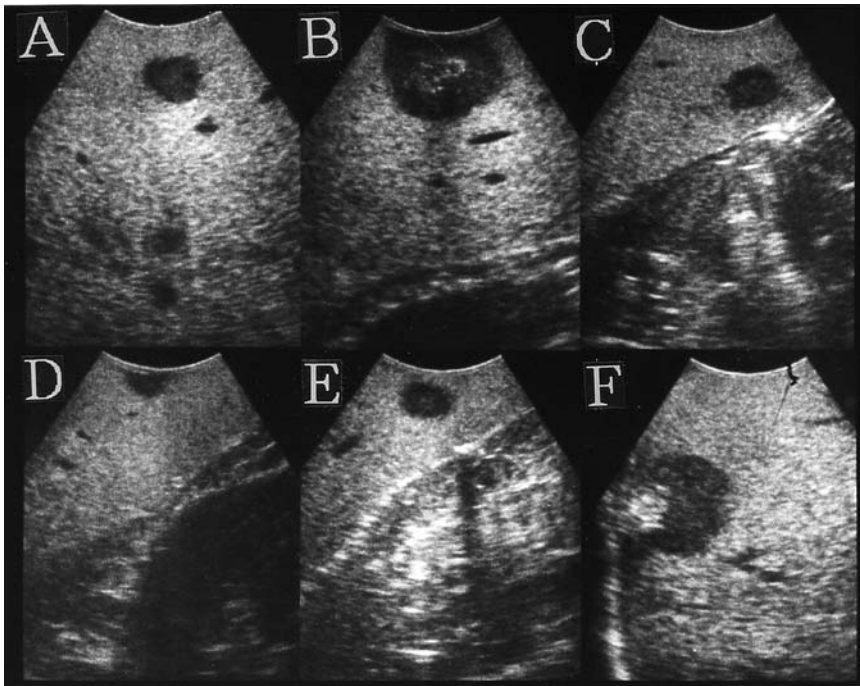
Intraoperative ultrasonography images at the first hepatectomy. One nodule in segment 5 (A), three nodules in segment 6 (B–D), and one nodule in segment 7 (E) and segment 8 (F) are identified
